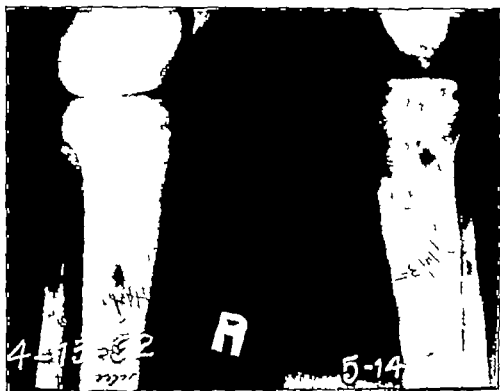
Osteogenic sarcoma, chondroblastic type, upper end of tibia. Patient first examined by interns and dismissed, as roentgenograms apparently negative. Returned in one month with definite tumor mass and beginning destruction of bone in region of condyles of tibia. Treated by low thigh amputation.
